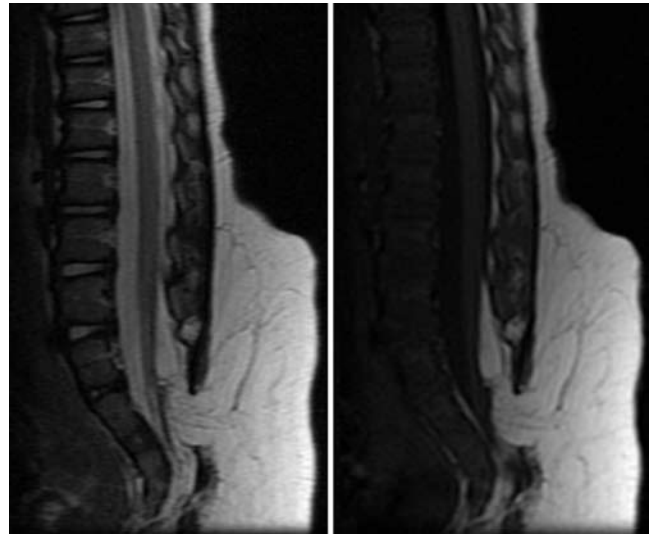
Sagittal T2-weighted (left) and T1-weighted (right) MR images revealing a lipomyelomeningocele tethering the conus at S-2 in an infant with extra vertebral segments, anal atresia, absent kidney, hypospadias, and absent radius.
